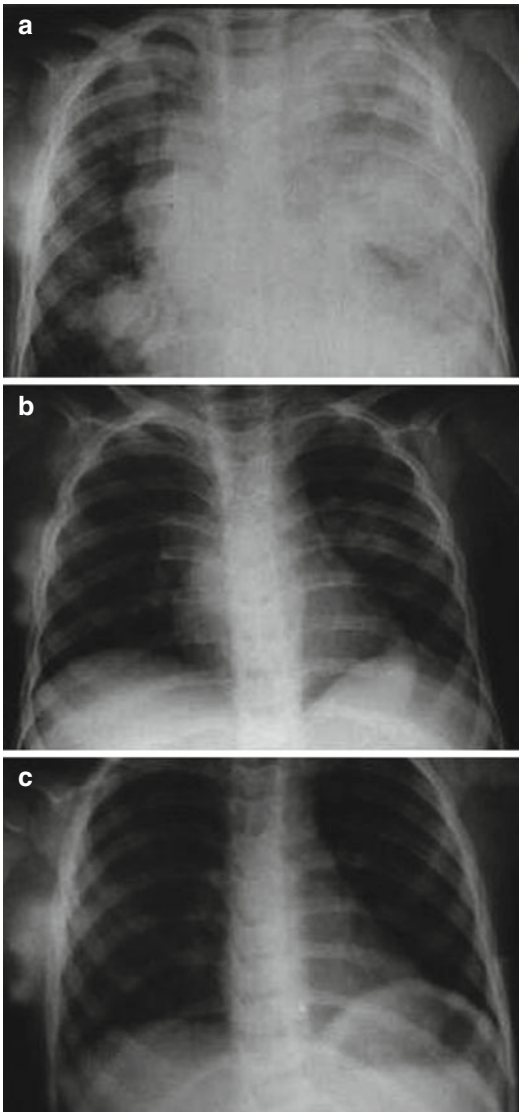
(a) A chest radiograph in a patient with Wilms' tumor presenting with pulmonary disease. (b) The same patient's chest radiograph after 4 weeks of chemotherapy with vincristine, actinomycin D, and doxorubicin. (c) The same patient's chest radiograph after 4 more weeks of chemotherapy and radiotherapy
